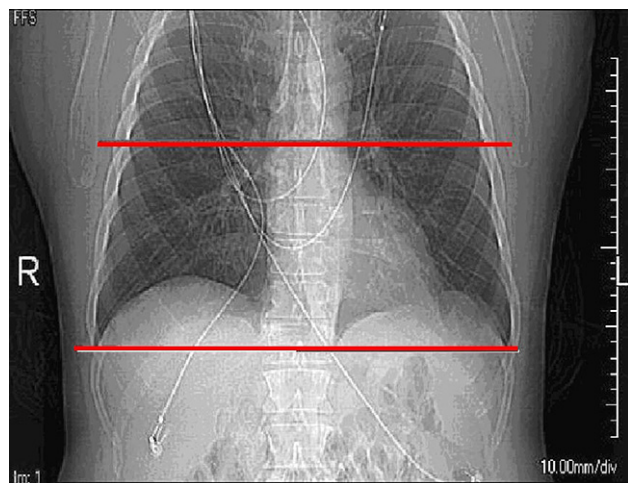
Measurement of chest lateral width on the topogram and determination of noise level in the ascending aorta. Chest lateral width is measured on the topogram from skin to skin at the level of the left hemidiaphragm, as shown in the images on the left. Noise levels are measured in axial slices on the non-contrast CT dataset as shown in the images on the right, by placing a circular region of interest in the ascending aorta at the level of the coronary ostia. Image noise is expressed as the standard deviation of the attenuation values within the region of interest, in Hounsfield units.
